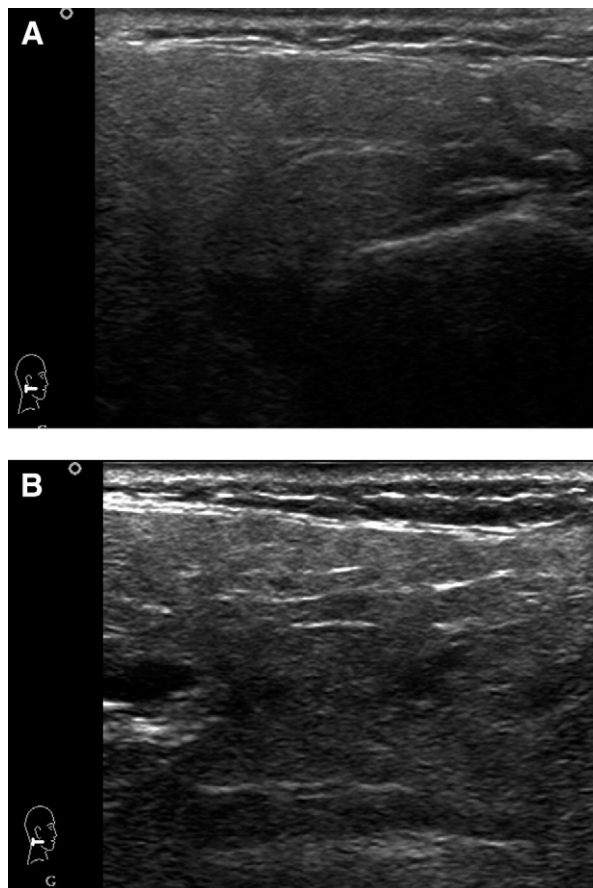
Sonograms of the parotid glands scanned parallel to the occlusal plane (left = posterior; right = anterior). A, Sonogram of normal parotid gland (grade 0). Internal echoes are homogeneous. B, Sonogram of parotid gland of Sjögren syndrome (grade 3). Internal echoes are evident and inhomogeneous. Multiple scattered hypoechoic areas (2-6 mm) are observed.
